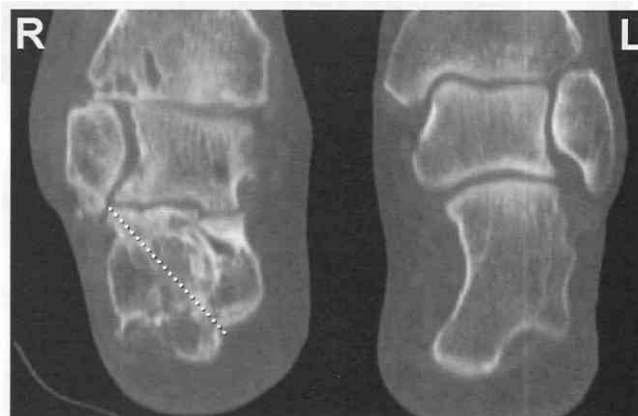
Coronal reconstruction CT image showing the healed right calcaneal fracture (dotted line). There is secondary osteoarthritis at the ankle and subtalar joints. The normal left hindfoot is included for comparison.
